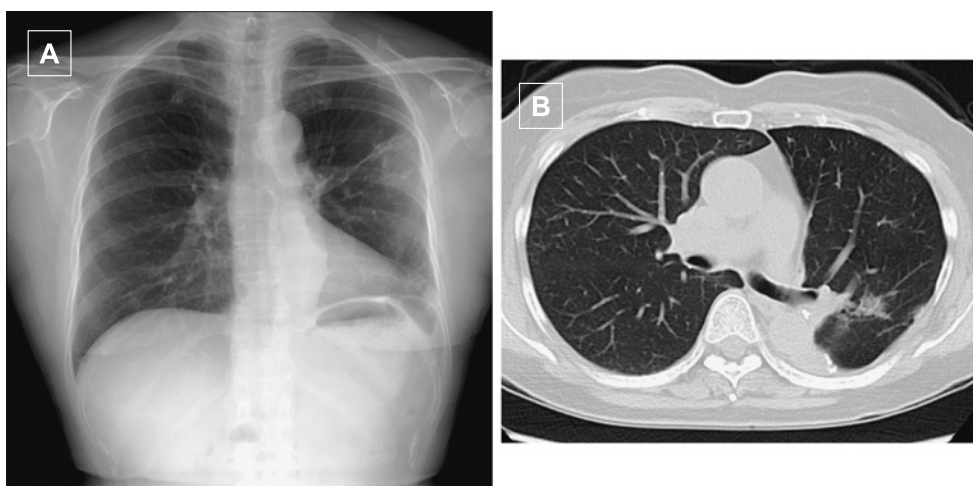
(A) Chest X-ray on admission revealed a dense focal lesion in the upper left lung field. (B) Computed tomography of the chest 2 months prior to admission revealed a dense focal lesion in the left S<sup>1+2c</sup>. Internally, lesion appeared heterogeneous and the border was irregular.
